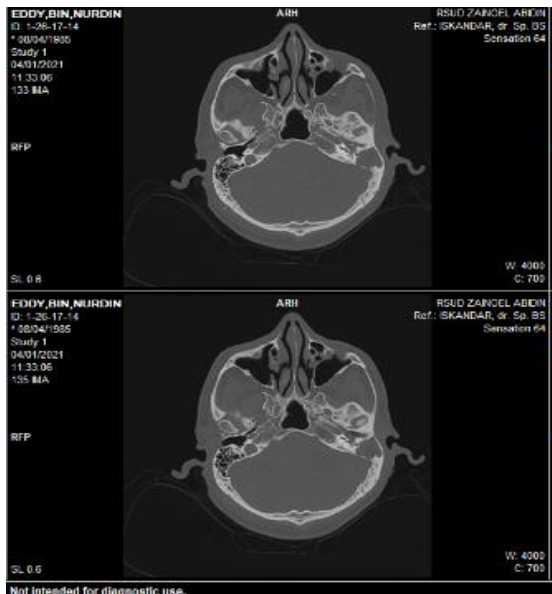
Mastoid CT-Scan
